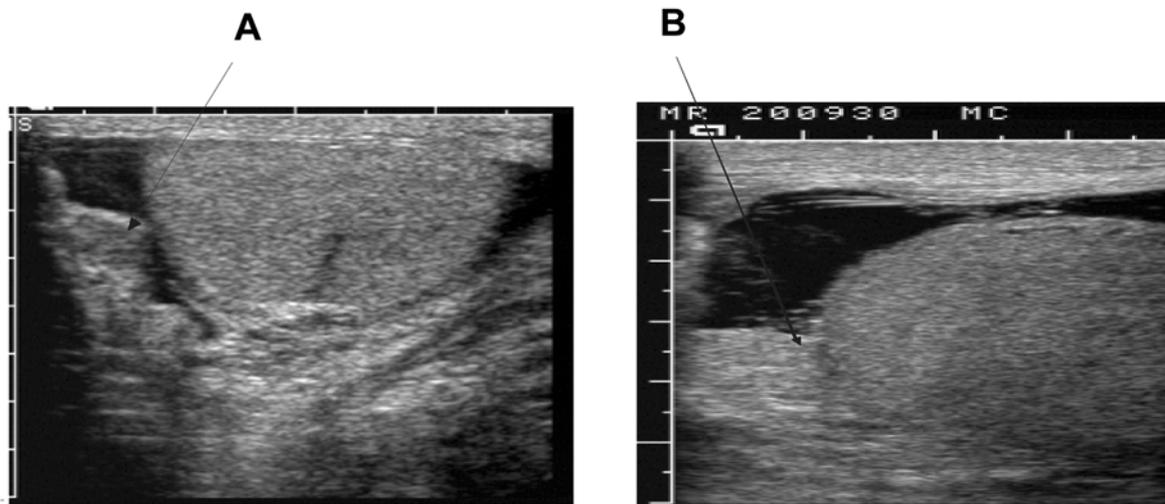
Testicular ultrasound showing a normal right epididymis (A) and an enlarged and thickened left epididymis (B).
